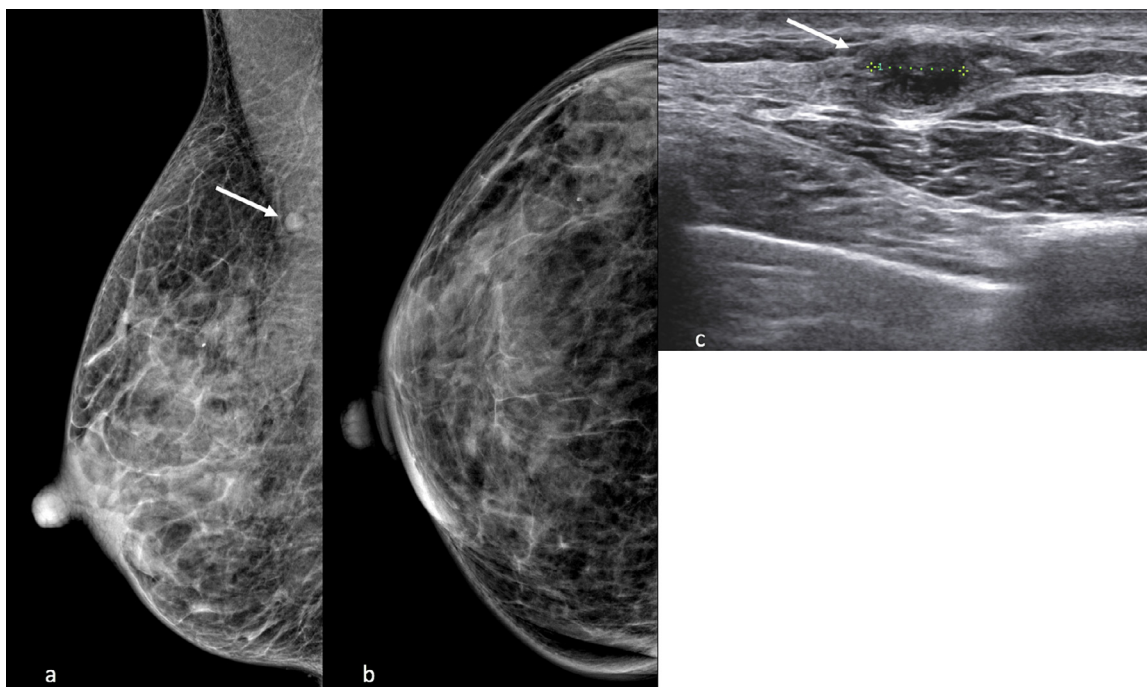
Medio-lateral oblique (a) and craniocaudal (b) mammograms show an oval circumscribed dense mass in the upper-outer quadrant of the right breast (arrow). On ultrasound (c) the mass is hypointense and show circumscribed margins and posterior enhancement.
